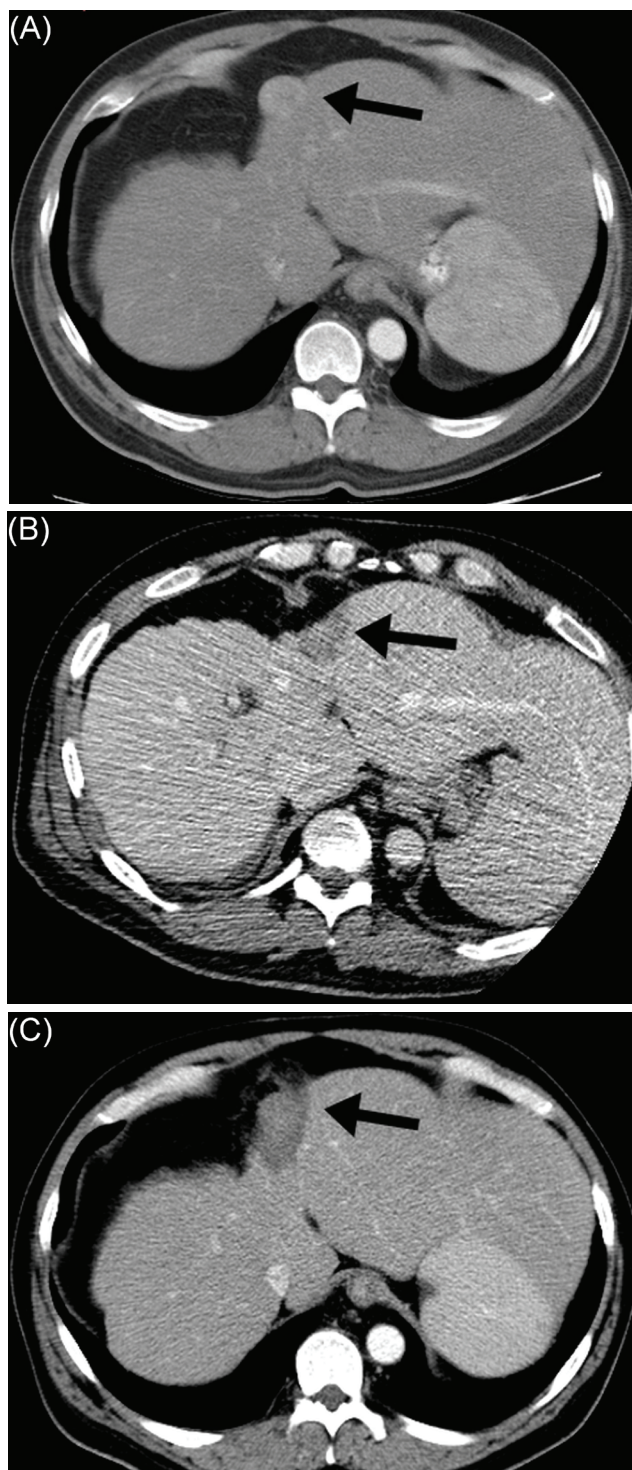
Arterial-phase enhanced computed tomography imaging of the liver at similar levels demonstrates the enhancing nodule (arrows) (A) 10 days before treatment, (B) minutes after treatment, and (C) 1 month after treatment with radiofrequency ablation and heat-deployed liposomal doxorubicin.
